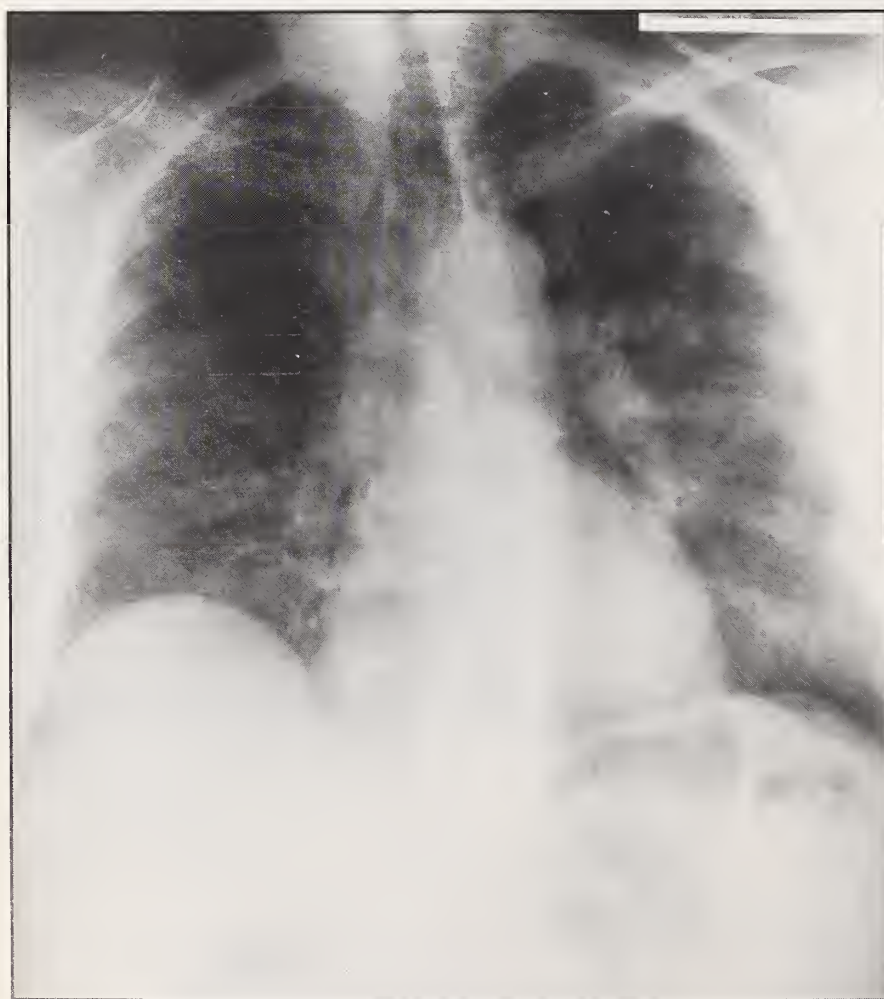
Admission chest roentgenogram showing bilateral interstitial and alveolar infiltrates predominantly in the bases.
